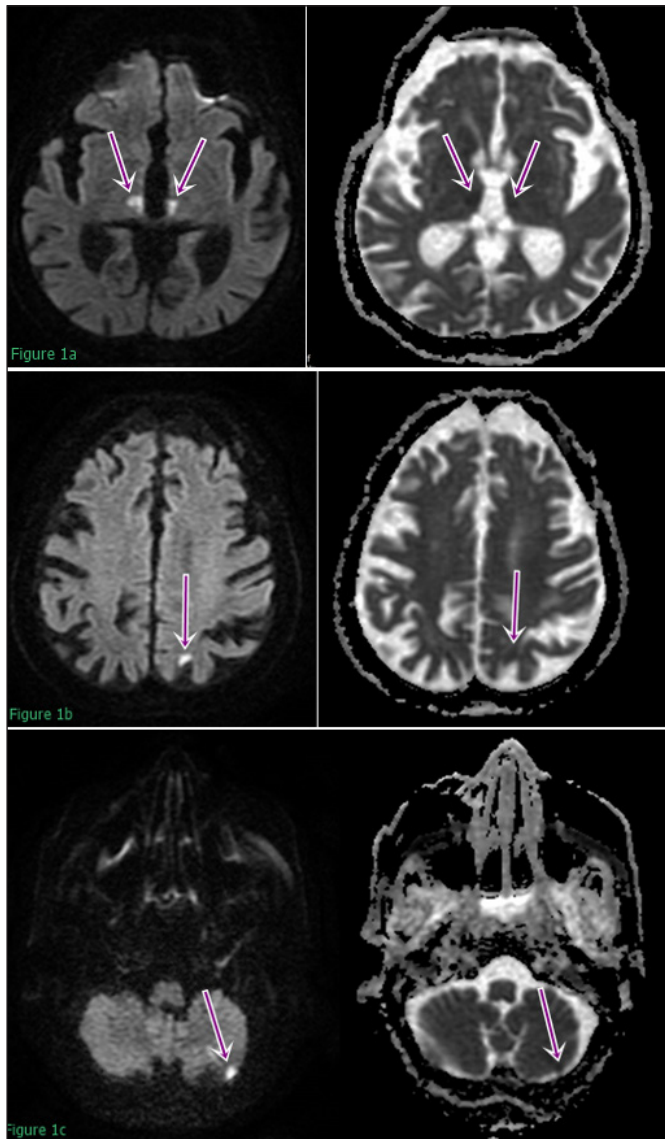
Diffusion-weighted magnetic resonance images showing millimetric foci showing diffusion restriction consistent with acute infarction in a) both thalami, b) left occipital lobe, and c) left cerebellar hemisphere
